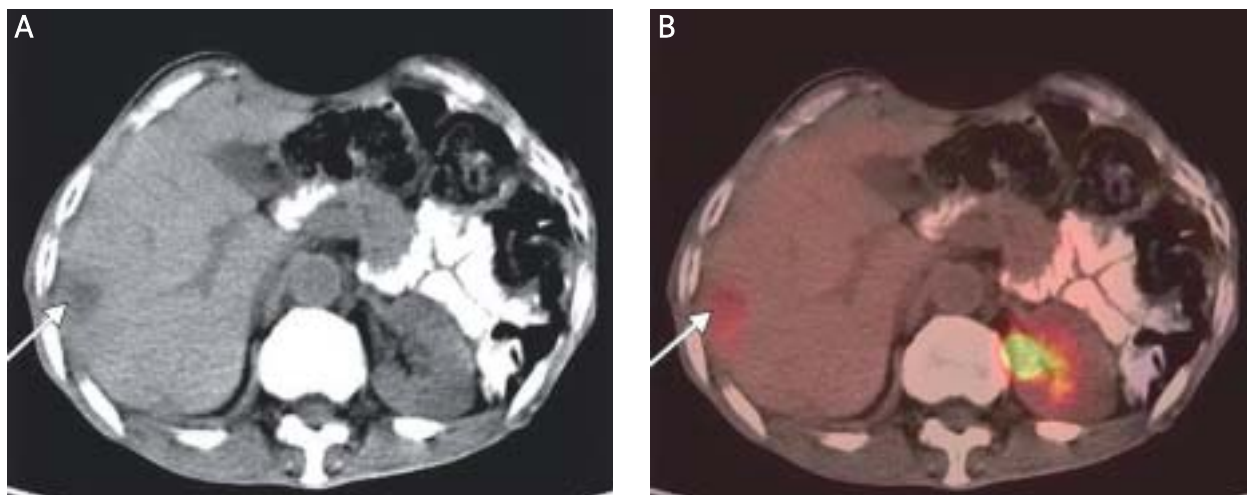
Post brachytherapy PET-CT scan images. CT scan (A) shows no significant change in the size of the mass, however it had developed a necrotic area. PET scan image (B) shows no significant FDG uptake in the lesion (SUV 2.3)
